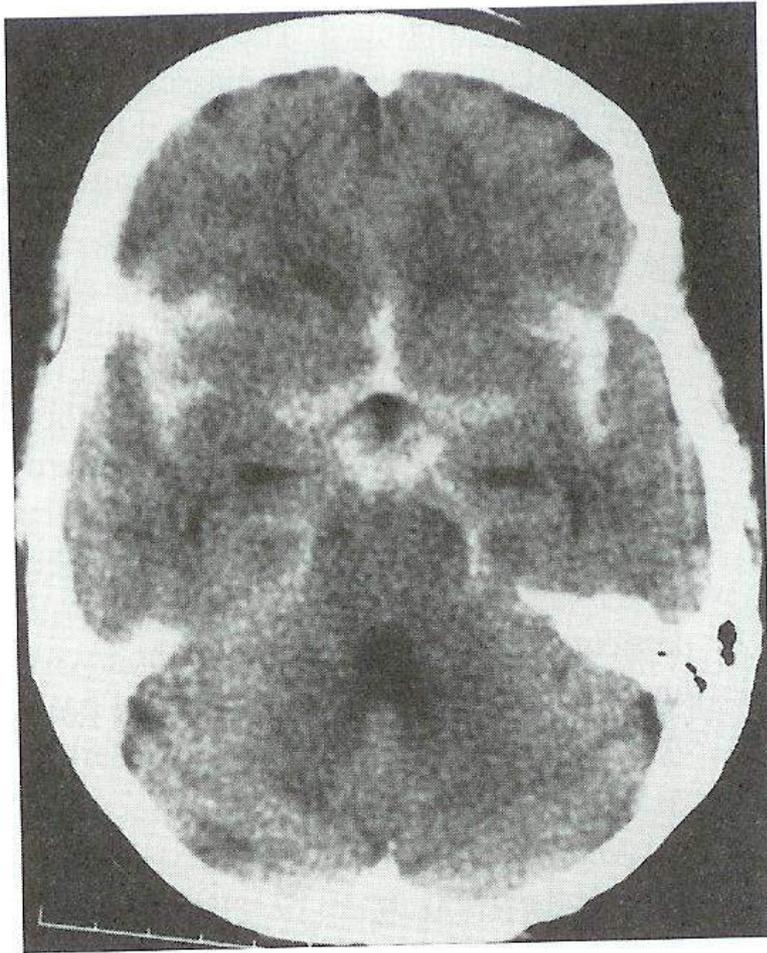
Diffuse subarachnoid blood seen on a noncontrast computed tomography brain scan. This patient had a rupture of a right middle cerebral artery aneurysm.
